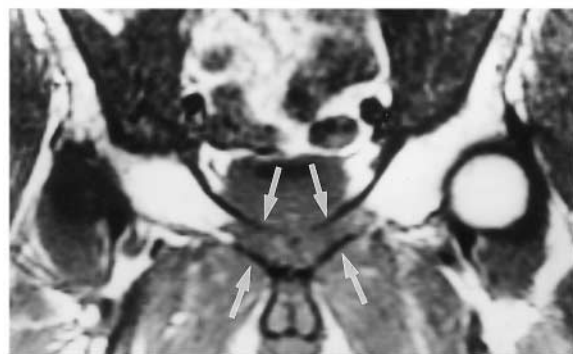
MR Imaging of the irradiated pubic bones after radiation therapy in a 65-year-old male with cancer of the prostate. Coronal T1-weighted (600/20) images demonstrate the irradiated pubic bones at 12 months (a) and at 26 months (b) after radiation therapy. At 12 months post-treatment, abnormal signal intensity reflecting oedema can be seen (arrows). At 26 months after therapy, the oedema has almost completely disappeared.
